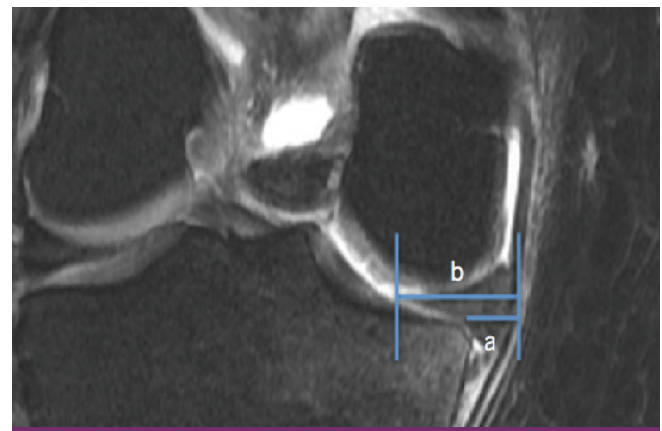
Coronal T2 MRI image of medial meniscus extrusion. Image taken in the mid-coronal plane deep to the medial collateral ligament. Meniscal subluxation index (MSI) = a/b . In this case, the MSI = 0.40. MRI courtesy of Naveen Murthy, MD, Mayo Clinic.
